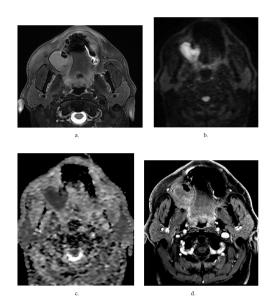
(case 19). A 53-year-old man with mandibular lymphoma. (a) Axial fat-suppressed T2, (b) diffusion-weighted imaging, (c) ADC imaging, and (d) postcontrast fat-suppressed T1A sequences in contrast-enhanced facial MRI, T2W hyperintense, DWI hyperintense, and markedly low ADC values, causing expansion in the corpus of the right mandible and bone destruction lesion with faint and mostly peripheral enhancement in postcontrast series.
